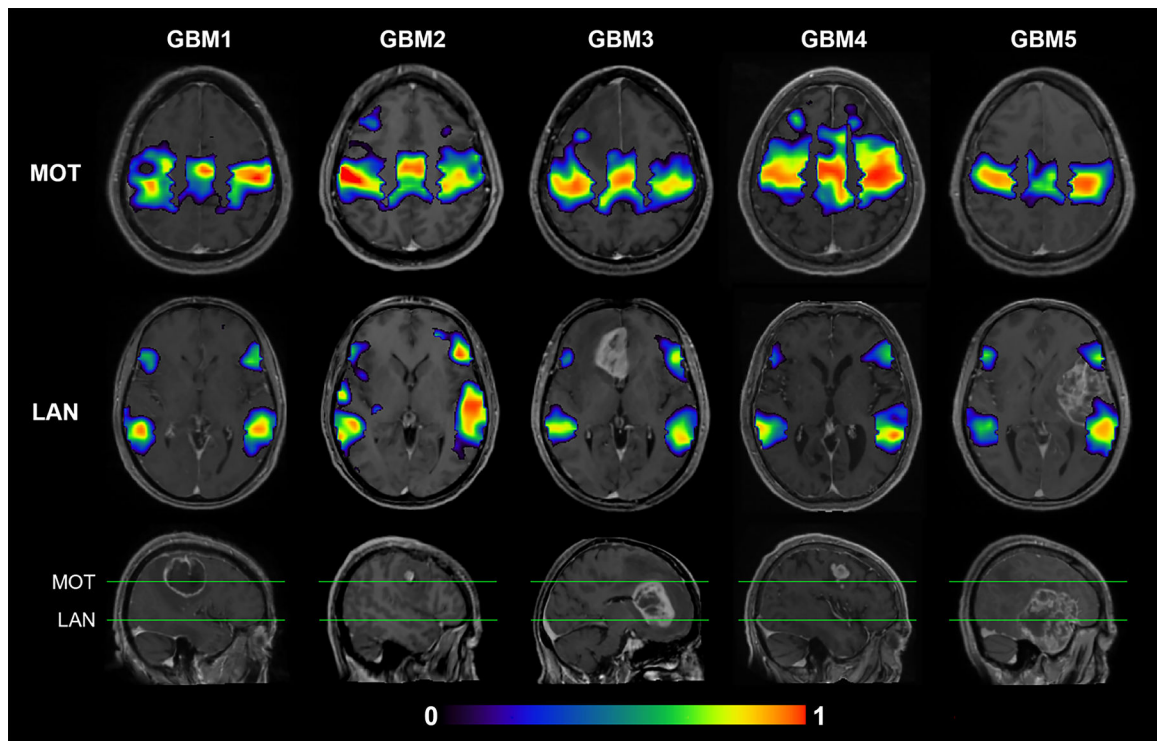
3DCNN mapping of language and motor networks using 50 time points (2.5 minutes) in GBM patients. First and Second rows show mapping of the motor and language networks on anatomically similar slices of T1-weighted post contrast images. Bottom row shows sagittal structural views of the tumor. Green lines indicate the slice level used in the top two rows. Despite the presence of a tumor, the 3DCNN was able to map LAN and MOT in regions associated with those networks.
